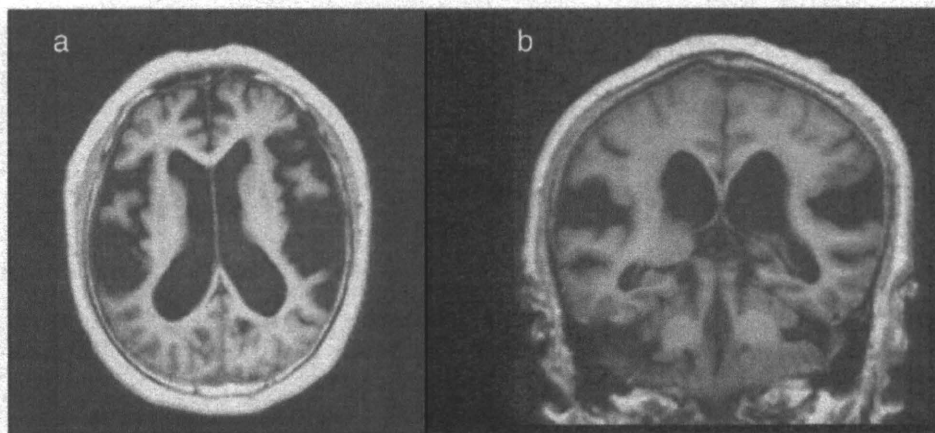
Brain MR images of a NOS patient. (a) and (b) are MR images of an 80-year-old male patient with NOS (NOS 4). His MMSE score was 28/30. NOS: suspected iNPH patients with no objective symptoms. Lateral ventricle dilatation (Evans index >0.3), narrowed subarachnoid spaces at the high convexity, and dilation of sylvian fissure and basal cistern are observed in the patient.
